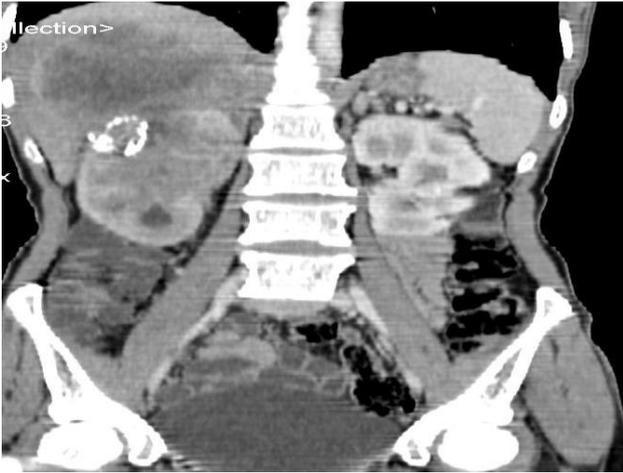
CT image: tumour mass at superior pole of right kidney contiguously extending to liver.
